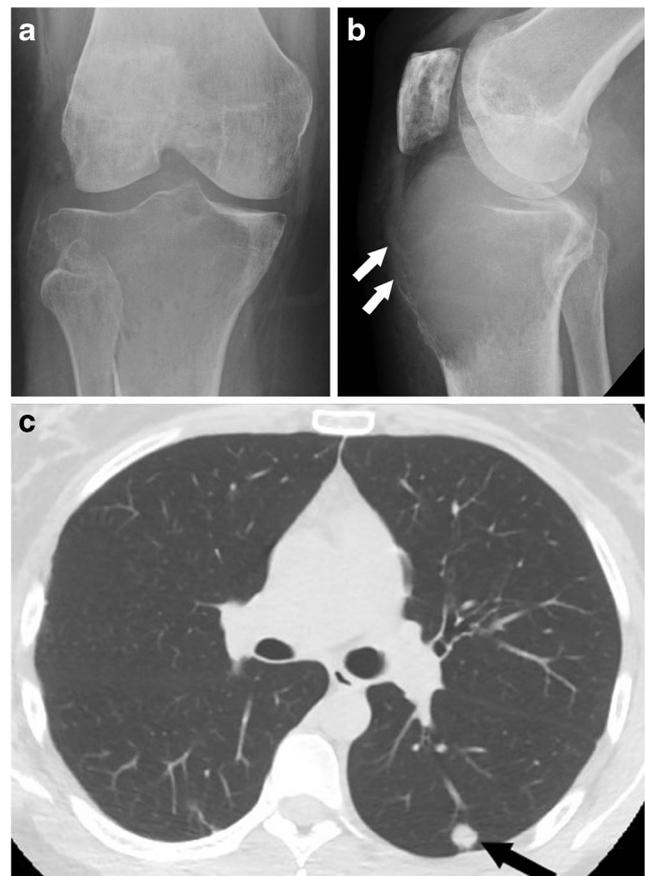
A 28-year-old patient with a Campanacci stage III GCT of the proximal tibia who later developed lung metastasis. a Anteroposterior radiograph shows an osteolytic lesion with thinning of the cortex. b Lateral radiograph shows an osteolytic lesion with soft tissue extension (arrows). c CT of the chest shows a lung metastasis (arrow)
